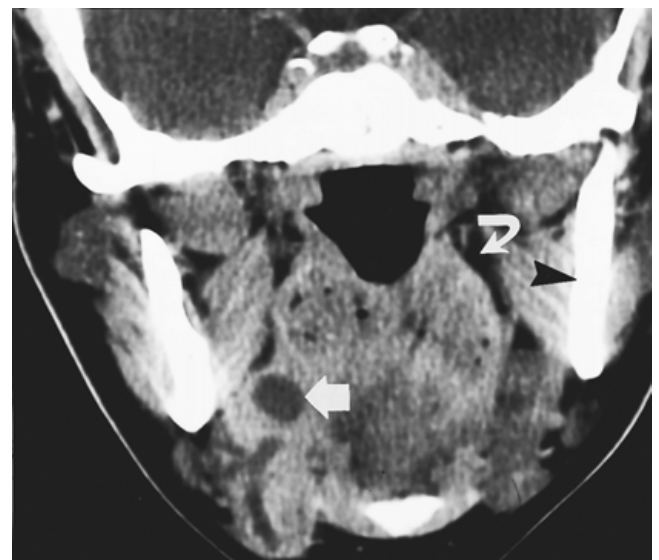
Obstructed submandibular duct. Coronal computed tomographic scan of the oral cavity shows dilated submandibular duct within the right side of the floor of the mouth (straight arrow). The curved arrow points to fat within the parapharyngeal space. The arrowhead points to the mandible within the masticator space.
